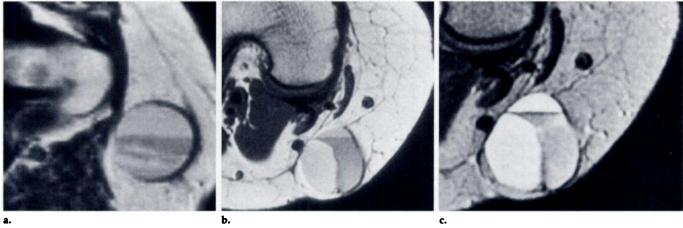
(a) Axial MR image (SE, 2,000/30) of the hip in a 72-year-old woman with a 7-cm infected hematoma in subcutaneous tissues, adjacent to the greater trochanter and gluteus medius. There is a fluid-fluid level, with a high-signal-intensity region above the inhomogeneous layer of lower signal intensity. Portions of the mass and the strands of peritumoral high signal intensity became more intense than fat on T2-weighted images. (b) Axial MR image (SE, 2,000/15) of the knee in a 51-year-old woman with a 3-cm telangiectatic osteosarcoma arising in the subcutaneous soft tissues, preserving fascial planes and deviating the medial head of the gastroenemius. Its margins are sharp, and it contains both a vertical and a horizontal septation, with two areas isointense to fat and one that is hyperintense to muscle but hypointense to fat. (c) Axial MR image (SE, 2,000/80) of the knee (second echo of image shown in b) shows that the tumor has increased in signal intensity, and the areas previously isointense to fat are now hyperintense to fat. Strands of peritumoral high signal intensity are minimal.
